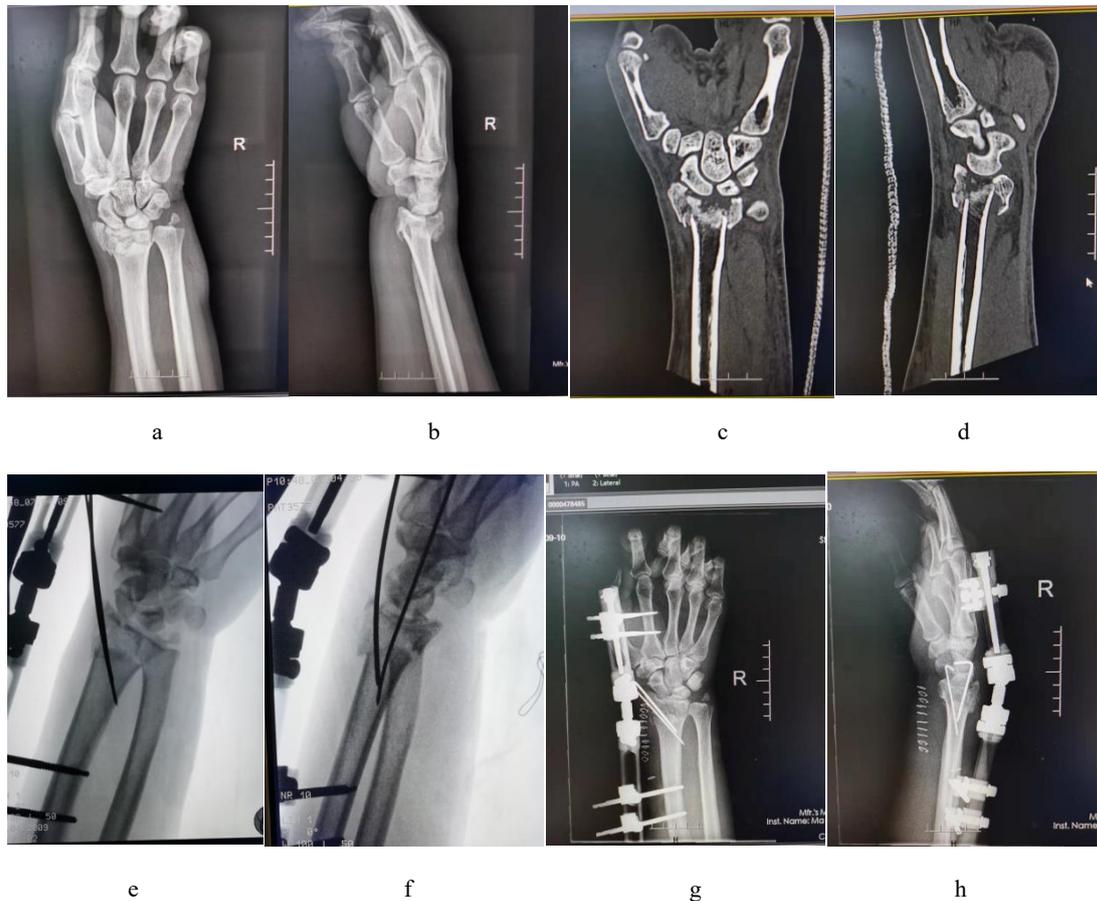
The patient, a 50-year-old male, AO type C3;(a,b,c,d) Preoperative plain radiographs and three-dimensional CT showed comminuted fracture of the distal right radius; (e,f) Intraoperative reduction using kapandji technique; (g,h) Postoperative radiographs showed good fracture reduction.
